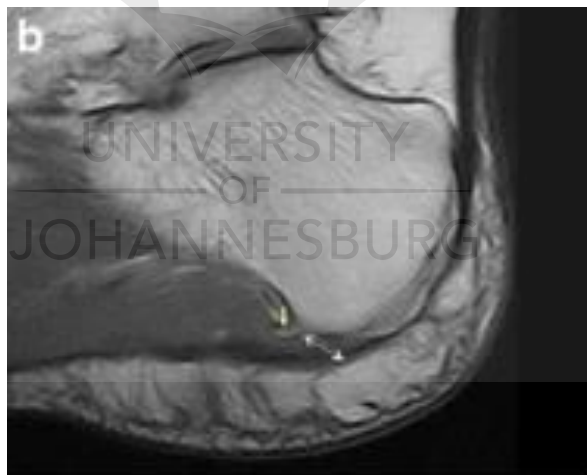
MRI (b). Arrow: Indicates heel (calcaneal) spur. Double-head arrow: Thickening of the plantar fascia origin on the calcaneus (Draghi et al., 2017)
